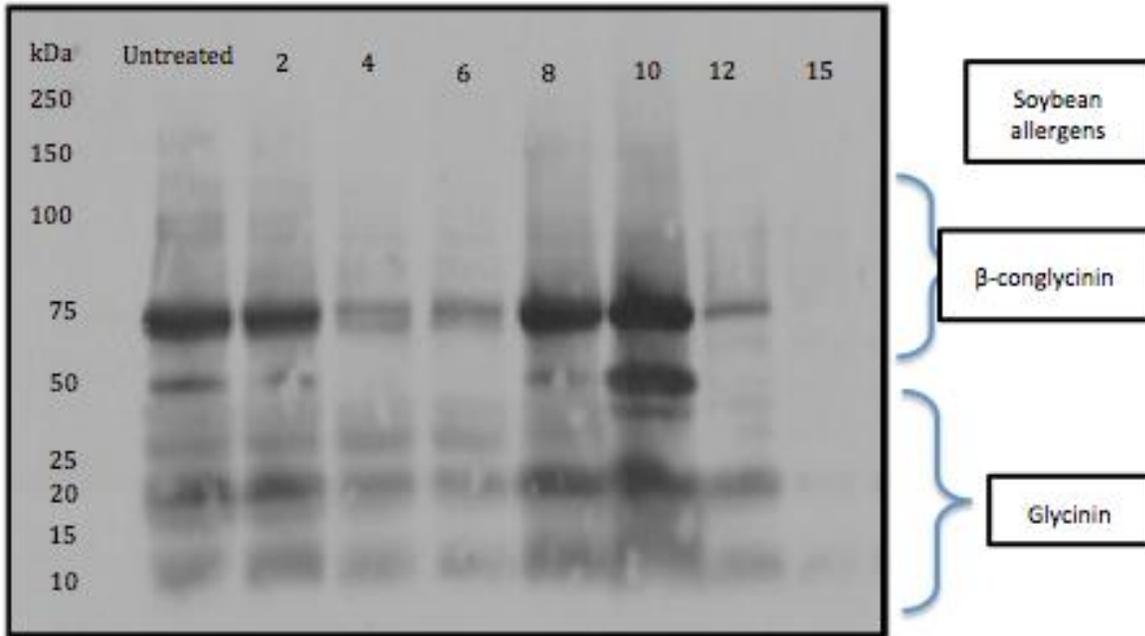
2. Western blot profile of power ultrasound treated soymilk for 2, 4, 6, 8, 10, 12 and 15 min, compared to untreated sample. Molecular weights expressed are in kDa.
